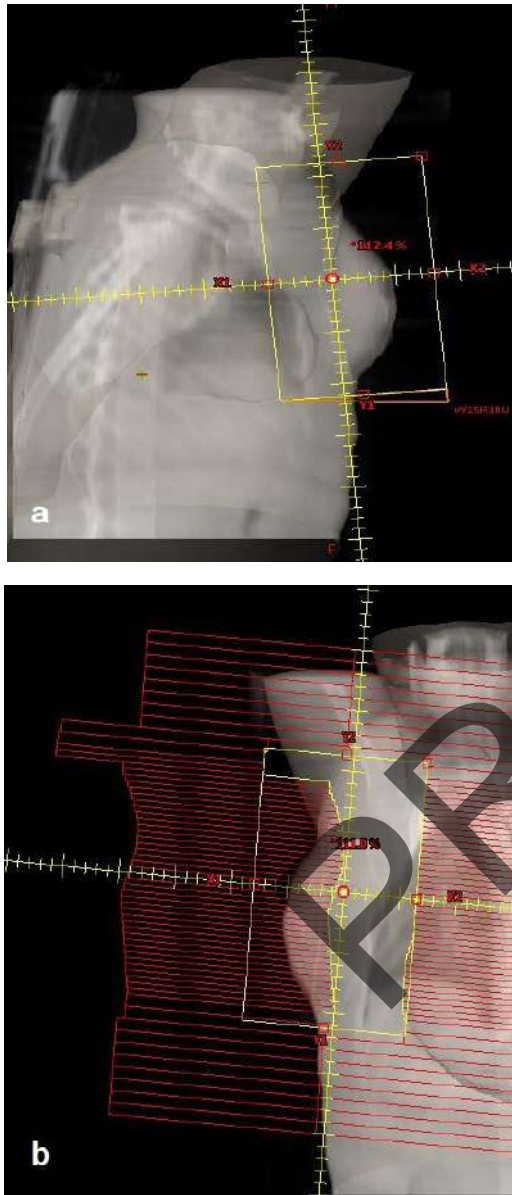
BEV (Beam's-eye view) with DRRs (digitally reconstructed radiography) for the wedged fields (a) and the FIF (b)
